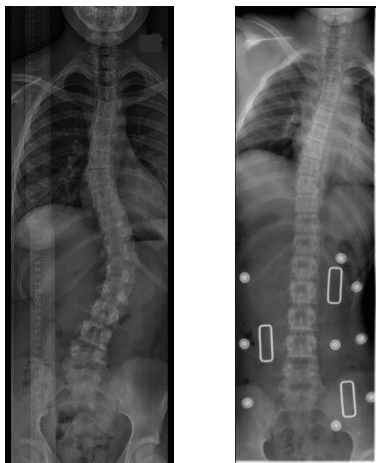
Standing radiograph of a patient without brace to the left and in a Boston brace to the right
